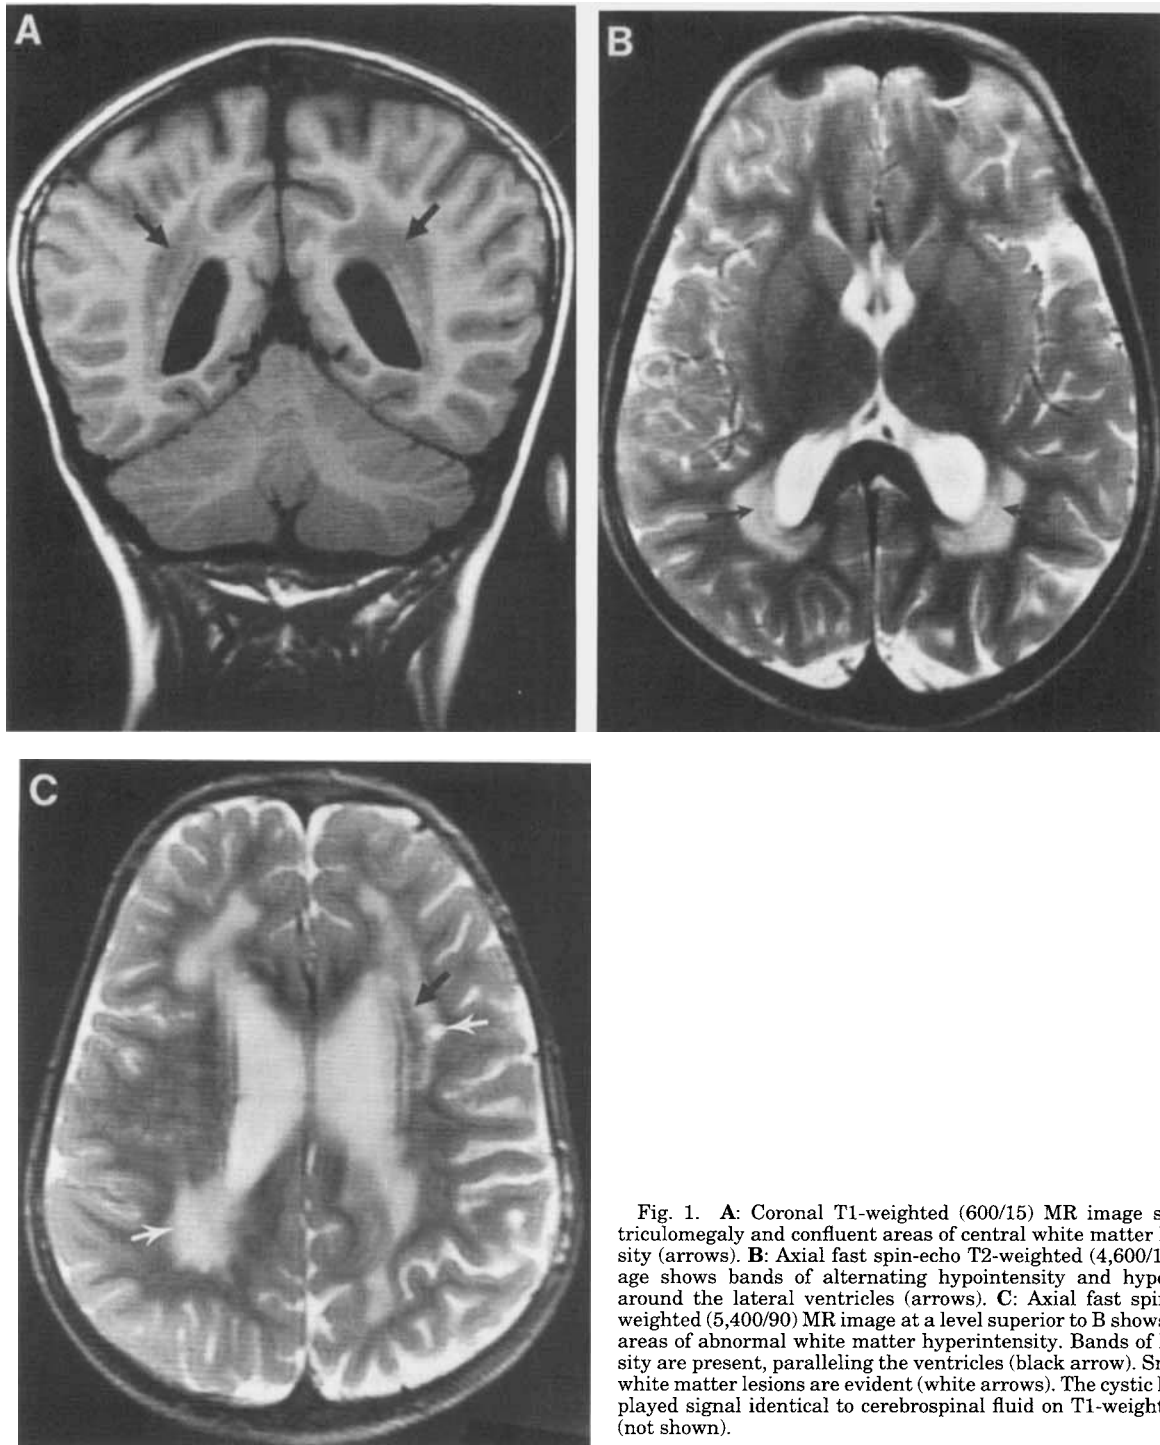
A: Coronal T1-weighted (600/15) MR image shows ventriculomegaly and confluent areas of central white matter hypointensity (arrows). B: Axial fast spin-echo T2-weighted (4,600/19) MR image shows bands of alternating hypointensity and hyperintensity around the lateral ventricles (arrows). C: Axial fast spin-echo T2-weighted (5,400/90) MR image at a level superior to B shows extensive areas of abnormal white matter hyperintensity. Bands of hypointensity are present, paralleling the ventricles (black arrow). Small, cystic white matter lesions are evident (white arrows). The cystic lesions displayed signal identical to cerebrospinal fluid on T1-weighted images (not shown).
